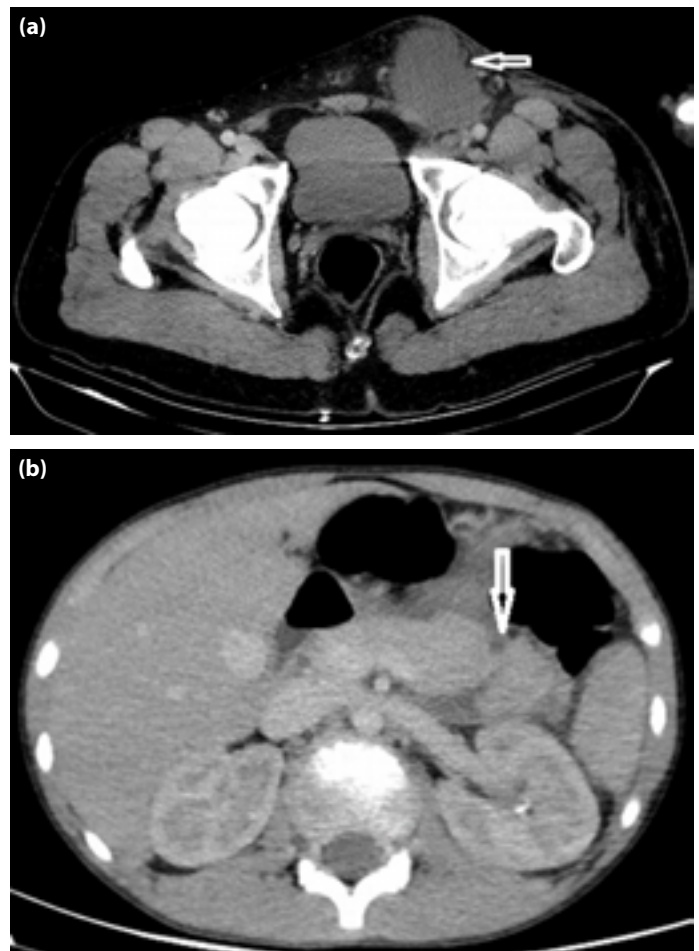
(a) Abdominal wall hematoma in a 30-year-old man with a handlebar injury. Axial contrast-enhanced CT image demonstrates an anterior pelvic wall hematoma (arrow) at the site of injury. (b) In a different patient, pancreatic transection consistent with an AAST grade 3 injury is present in the distal pancreas (white arrow).
